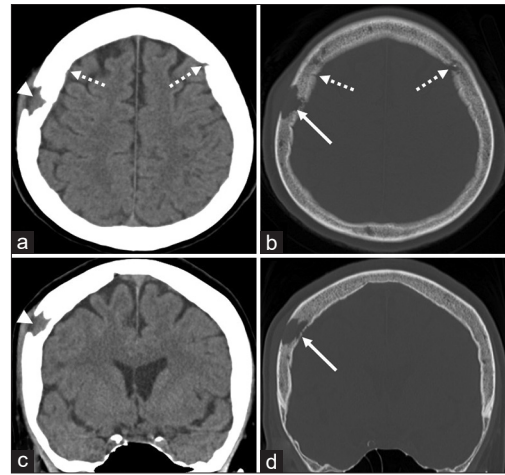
Axial (a) and coronal (c) computed tomography scans and their corresponding bone target images (b and d) showing an isodense mass in the right parietal bone (a and c, arrowhead) accompanied by irregularly shaped bone erosion mainly involving the diploe and outer table (b and d, arrow). The inner table is partially erosive (d, arrow). Dashed arrow: coronal suture.
